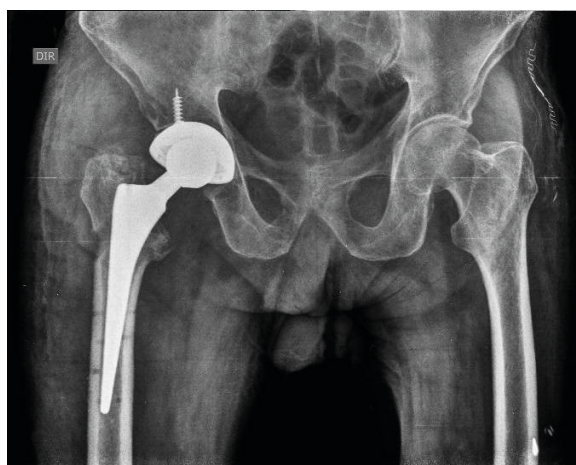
AP radiograph of the pelvis after SMR and THA on the right.
